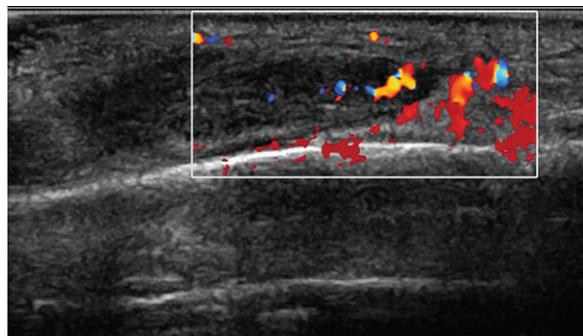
Doppler US image shows vessels within a hypoechogenic halo that surrounds a foreign body (not shown).
